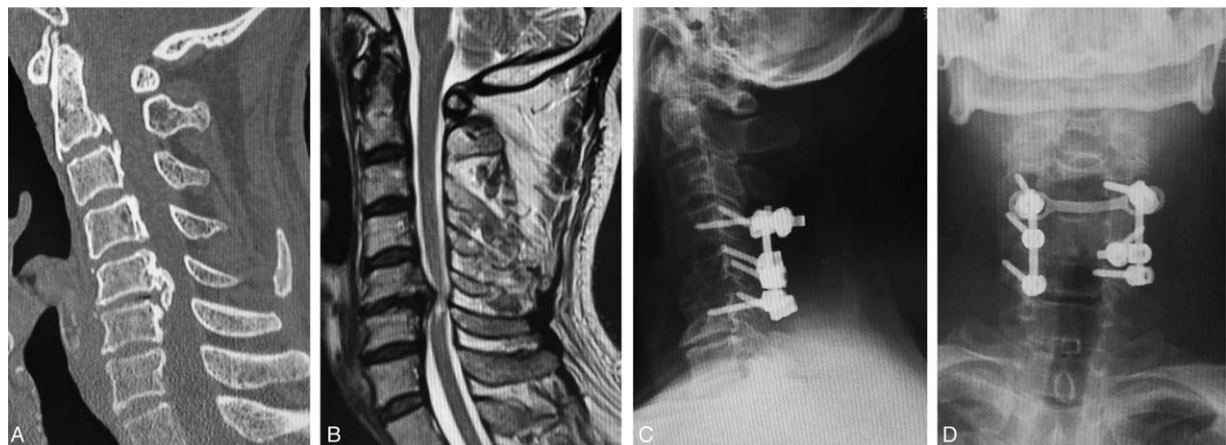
The patient was a 52-year-old man with cervical ossification of posterior longitudinal ligament (OPLL) presenting with cervical spondylotic myelopathy shown in (A) sagittal CT and (B) sagittal T2-weighted magnetic resonance imaging (MRI). (C, D) Posterior laminectomy with fusion using pedicle screws (C4–6) was performed.
